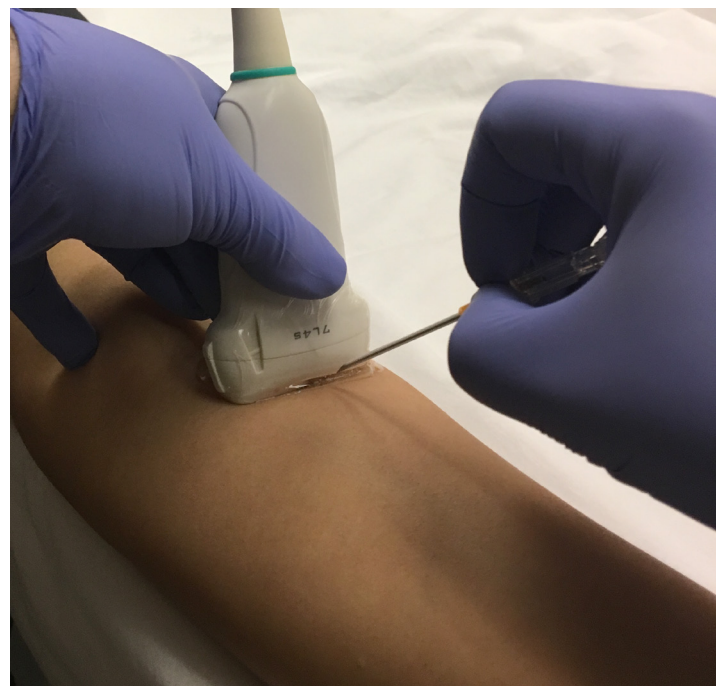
Ideal hand position for ultrasound-guided peripheral intravenous line placement.
